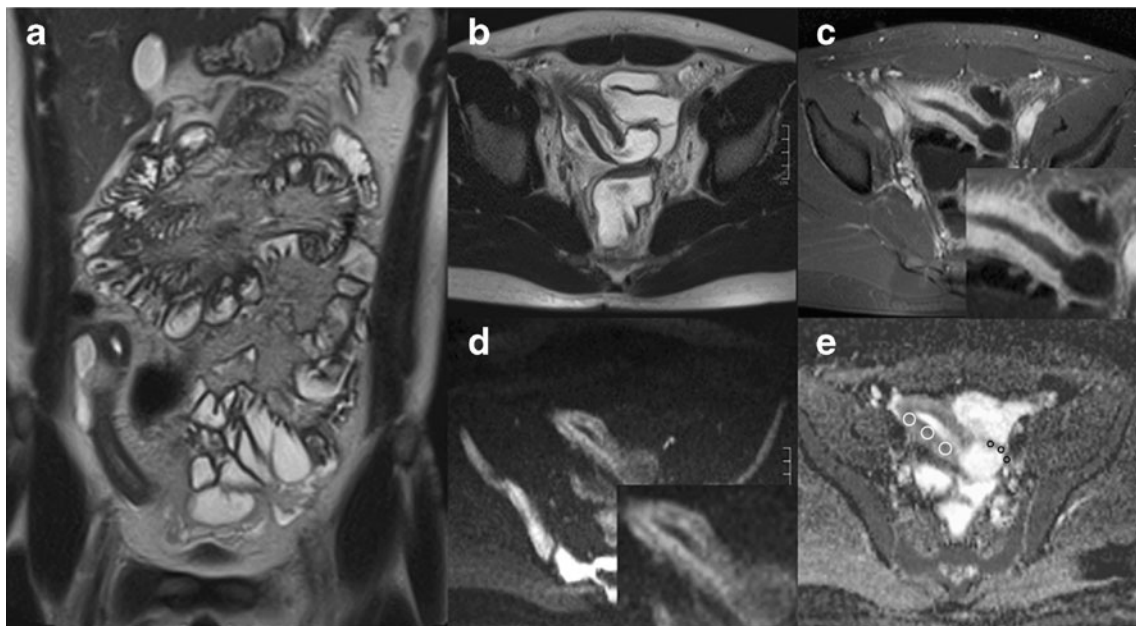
Newly diagnosed Crohn disease in a male patient with reduced physical fitness for 1 month. The patient did not report abdominal pain, fever or diarrhoea. leukocyte count was $5.5 \times 10^3/\mu\text{l}$, and serum CRP was elevated (2.35 mg/dl). Coronal and transverse T2-weighted HASTE images (a, b) show marked segmental wall thickening of the terminal ileum, and the corresponding two-layered signal increase on
